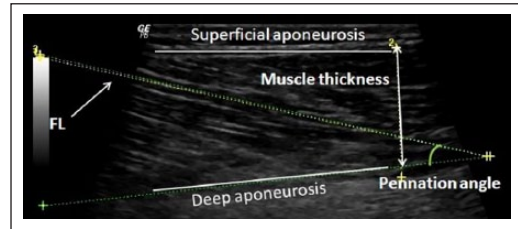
Ultrasonographic imaging of muscle demonstrating the measurement of the pennate angle, muscle thickness, and fascicle length.
